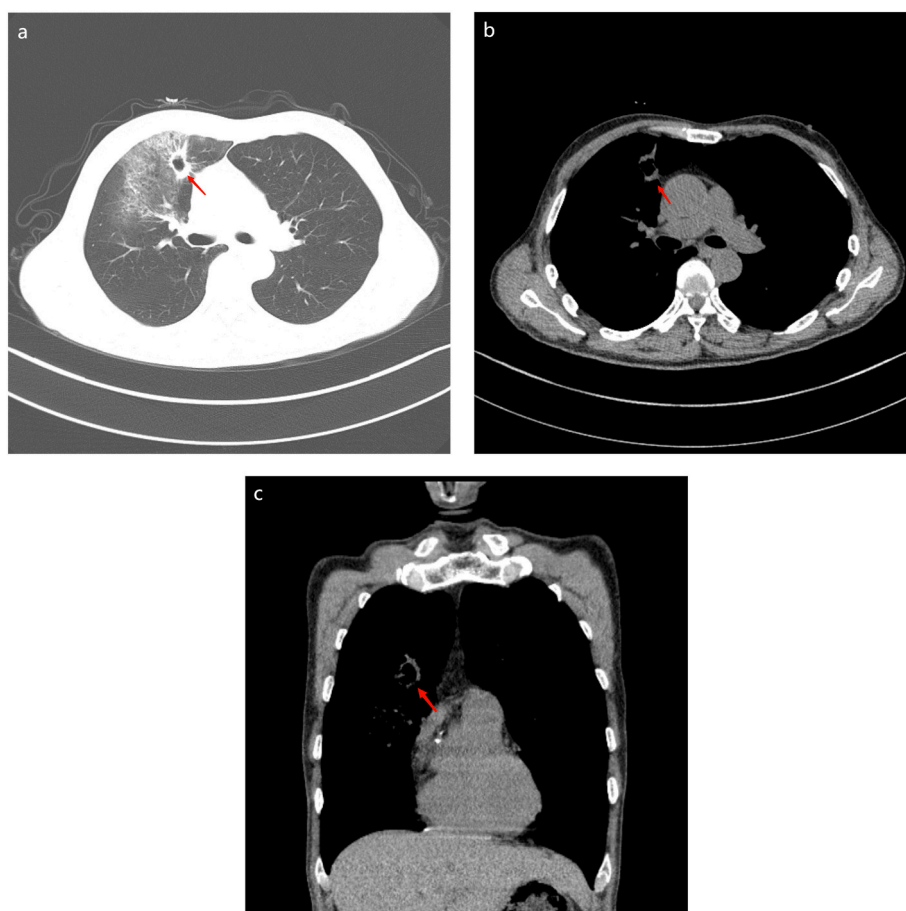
Thoracic computed tomography (CT) revealed an Eccentric posterior wall cavity of the upper lobe of the right lung.
